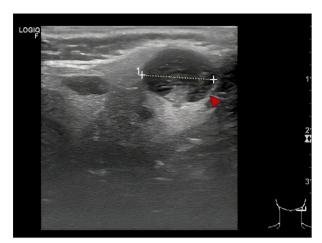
Presurgical imaging: An ultrasonographical examination revealed a smoothly circumscribed, homogeneous mass (1.4×1.2 cm, marked by an arrow).
